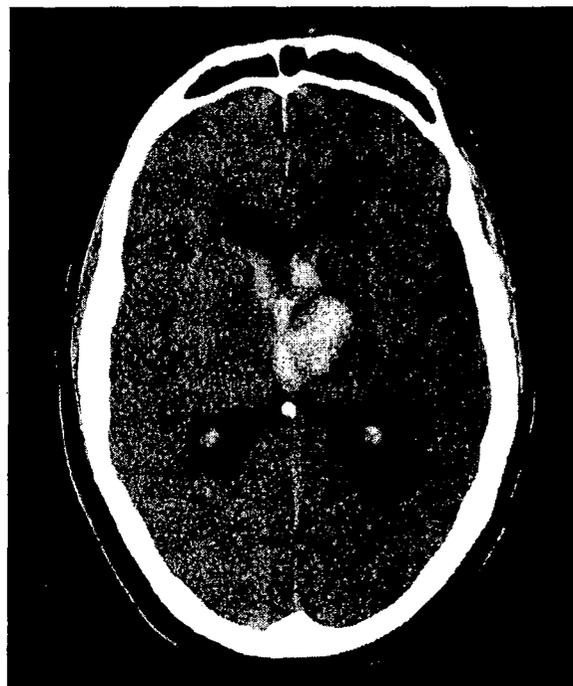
A non-contrast CT shows the left thalamic hemorrhage with blood in the third and lateral ventricles.
